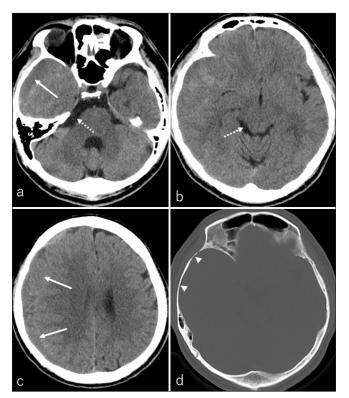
Axial computed tomography scans at presentation, taken (a) at the level of the inferior horn of the lateral ventricle, (b) third ventricle, and (c) upper lateral ventricle, showing slightly low-density areas in the right temporal, frontal, and parietal convexities (a and c, arrows). The cerebellopontine angle and ambient cisterns show dilation on the right side (a and b, dashed arrow). (d) A bone-target image at the same level as Figure (a) shows smooth-contoured erosive changes in the right temporal skull (arrowheads).
